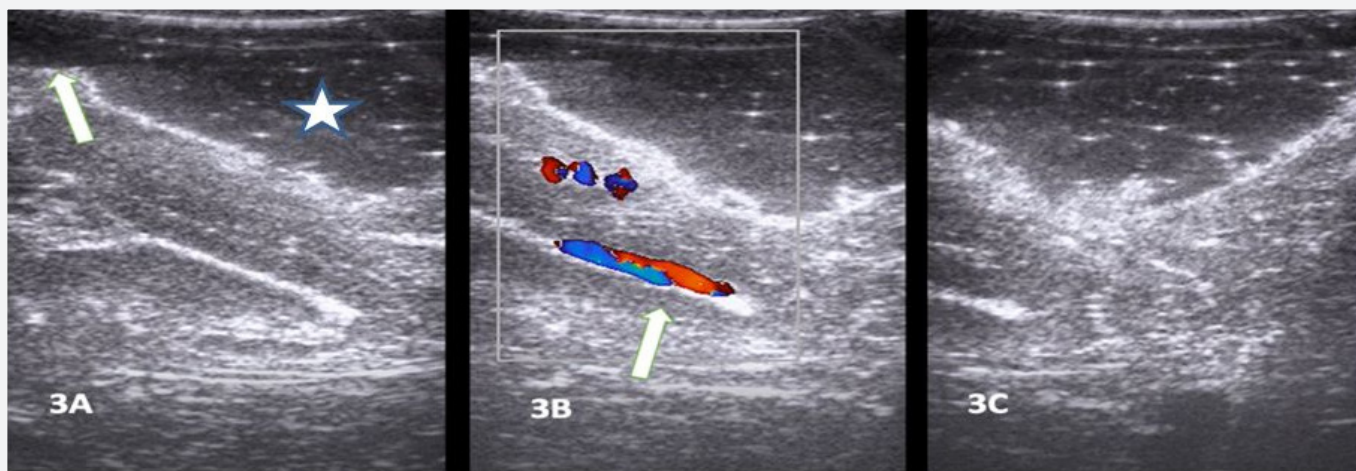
IOUS images after total excision of the tumor; 3A: Anechoic filled saline collection is observed in the extra axial area in the operation lodge (White star). No residual tumor lesion is observed in the images. Normal parenchyma is observed behind the fluid collection. 3B and 3C; Intraoperative Doppler examination reveals vascular structures in the parenchyma (white arrow)
